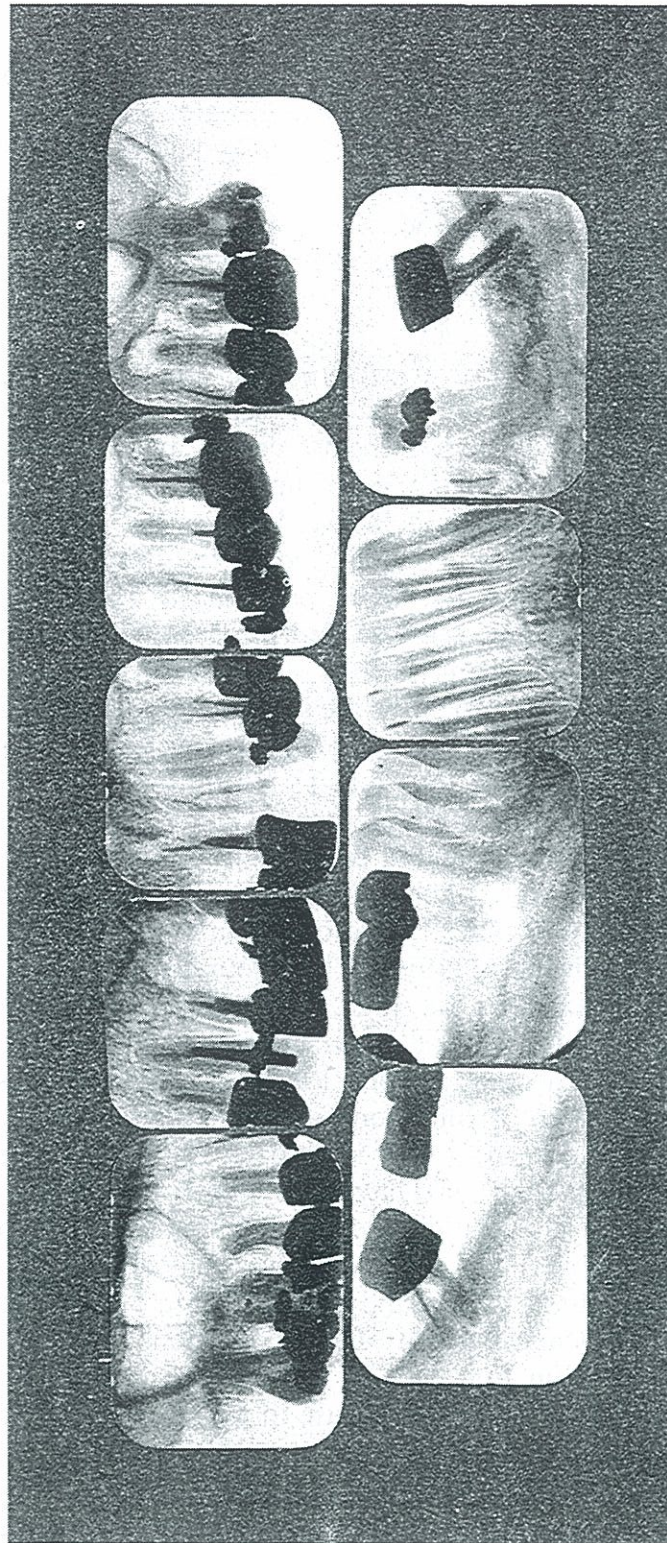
ROENTGENOGRAPHIC APPEARANCE OF TEETH OF CASE 1081. NOTE ZONE OF CONDENSING OSTEITIS SURROUNDING RAREFYING, PARTICULARLY OF UPPER RIGHT SECOND BICUSPID, CHARACTERISTIC OF A HISTORY OF A BROKEN HIGH DEFENSE. PATIENT SUFFERING FROM ACUTE PAIN AND LAMENESS IN RIGHT SHOULDER.
